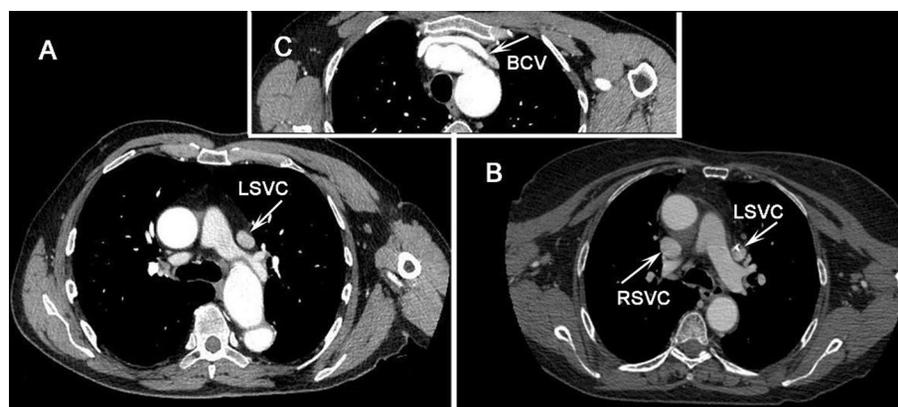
A, B. Differentiation of the detected left superior vena cava (LSVC) variations and their locations with respect to neighbouring anatomical structures based on axial computed tomography cross sections; A. Single persistent LSVC; male, 63 years old: a cross section at the level of Th7, (the vessel's lumen measures 18 mm at the level of Th6); B. Double superior vena cava; female, 80 years old: an axial cross section of both vessels; at the level of Th6 the LSVC lumen measures 15 mm, right superior vena cava (RSVC); 17 mm (the hyperdense structure within the LSVC lumen is a cardiac lead); C. Brachiocephalic vein (BCV): a "transverse" cross section at the level of Th3/Th4; the vessel's lumen measures 11 mm.
